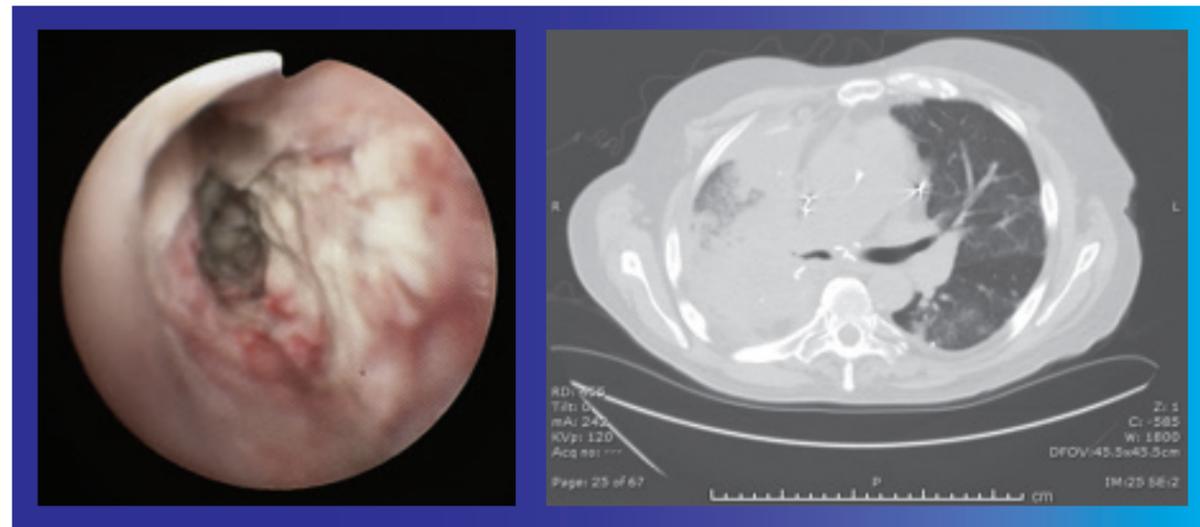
Bronchoscopy (left) and chest CT (right) pretreatment.
